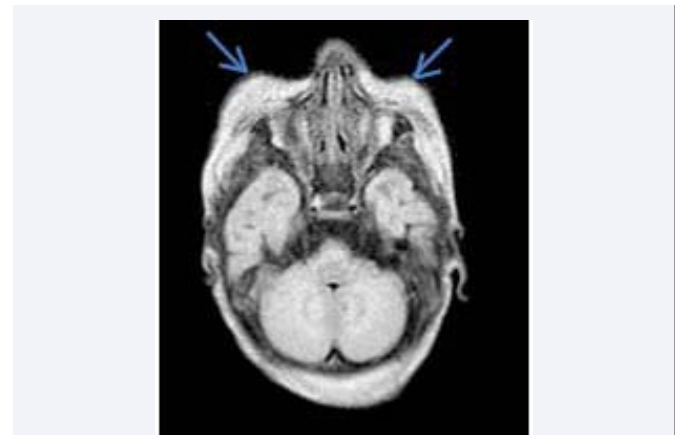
Case 3- MRI brain showing absent orbits.
